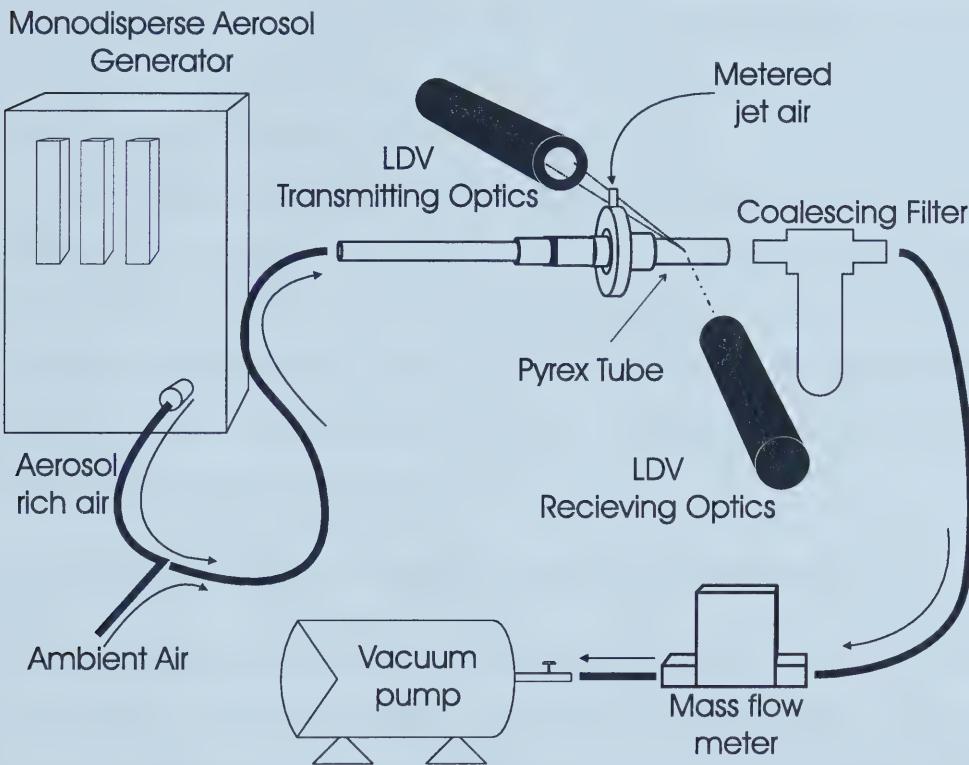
Experimental Setup For Laser Doppler Velocimetry
